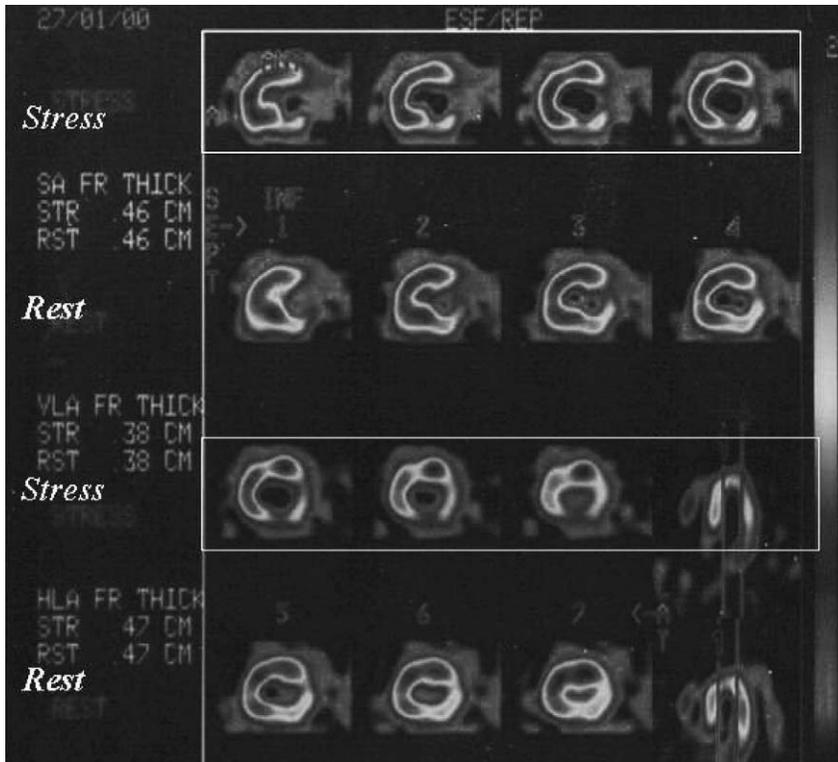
SPECT study showing different views of the heart after radioisotope administration. The images show the reversible changes under stress that recover at rest, suggesting the presence of ischemia.
